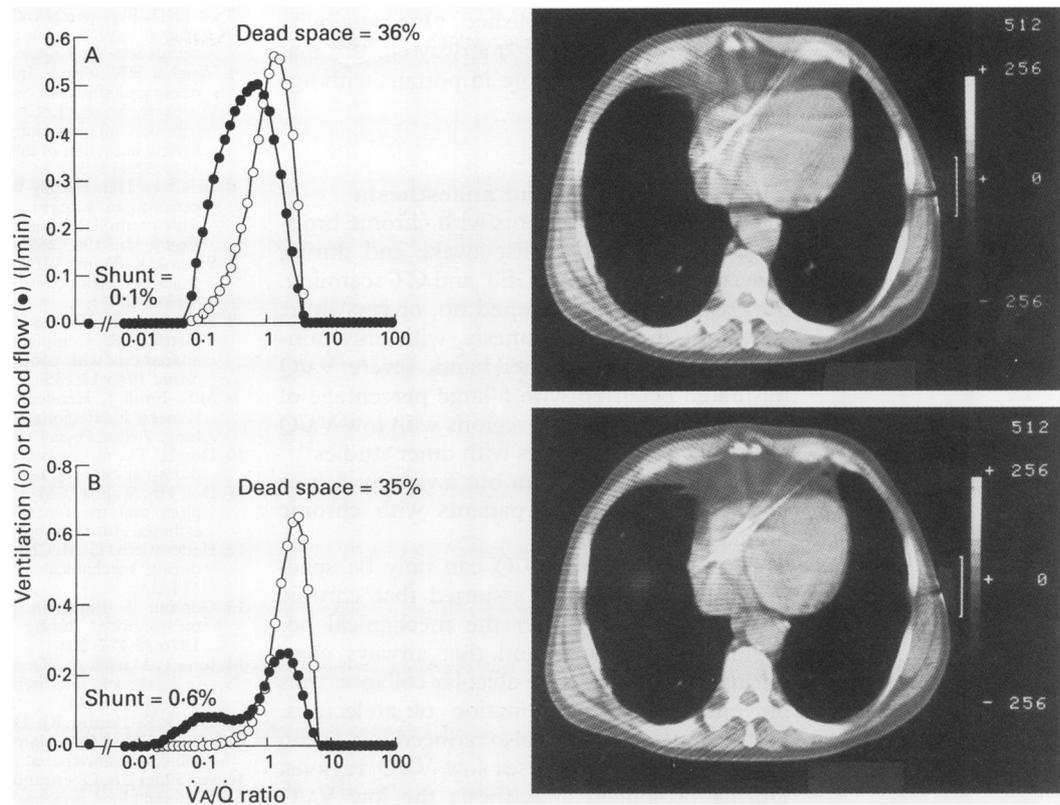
Ventilation-perfusion distributions and computed tomographic (CT) scans in a patient with severe COPD (A) when awake and (B) during inhalational anaesthesia. Note the large transverse lung area on the CT scan when awake which is unchanged during anaesthesia (compare with fig 3). There is no atelectasis and practically no shunt either when awake or anaesthetised. "Low" \dot{V}_A/\dot{Q} regions ($0.005 < \dot{V}_A/\dot{Q} < 0.1$) appear during anaesthesia. From Gunnarsson et al.⁵⁰
